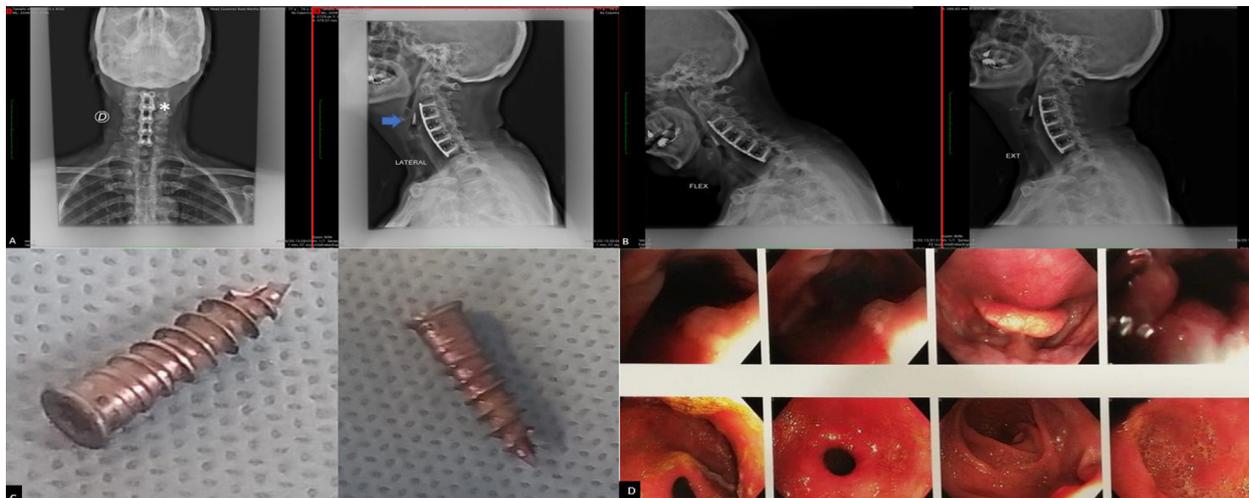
Image A, the migration of the cephalic left cervical screw is observed in the anteroposterior projection radiograph shown in figure | , and in the lateral radiography, the migration of the screw is mainly in the retropharyngeal space of 5 mm shown on the arrow. Image B shows the dynamic films in flexion and extension, demonstrating construct fixation with no instability. Image C shows the cervical screw spontaneously expelled through the upper airway 30 without leaving any clinical sequelae. Finally, figure D shows endoscopy images without perforation of the hypopharynx and esophageal walls is observed.
